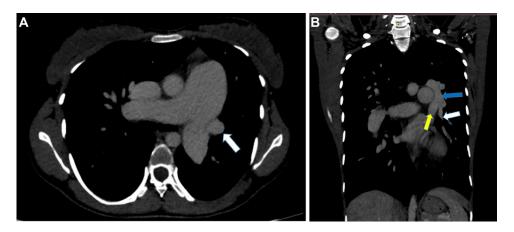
(A) Superior and inferior left pulmonary veins unite to form a common trunk (White arrow) – sagittal view (B) Coronal CT showing left superior pulmonary vein (White Arrow) and left inferior pulmonary vein (White Arrow) uniting to form a common trunk (Blue Arrow).
